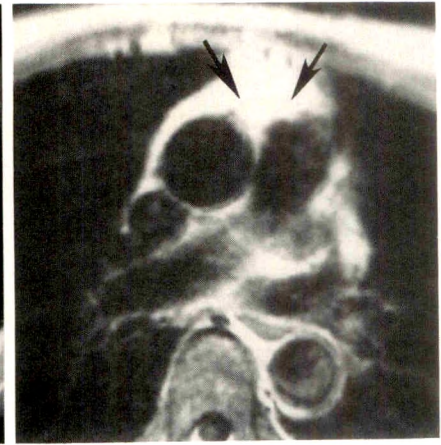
Spin-echo T1-weighted image of normal mediastinum in an adult. High signal intensity of normal thymus (arrows) is due to fatty replacement.
